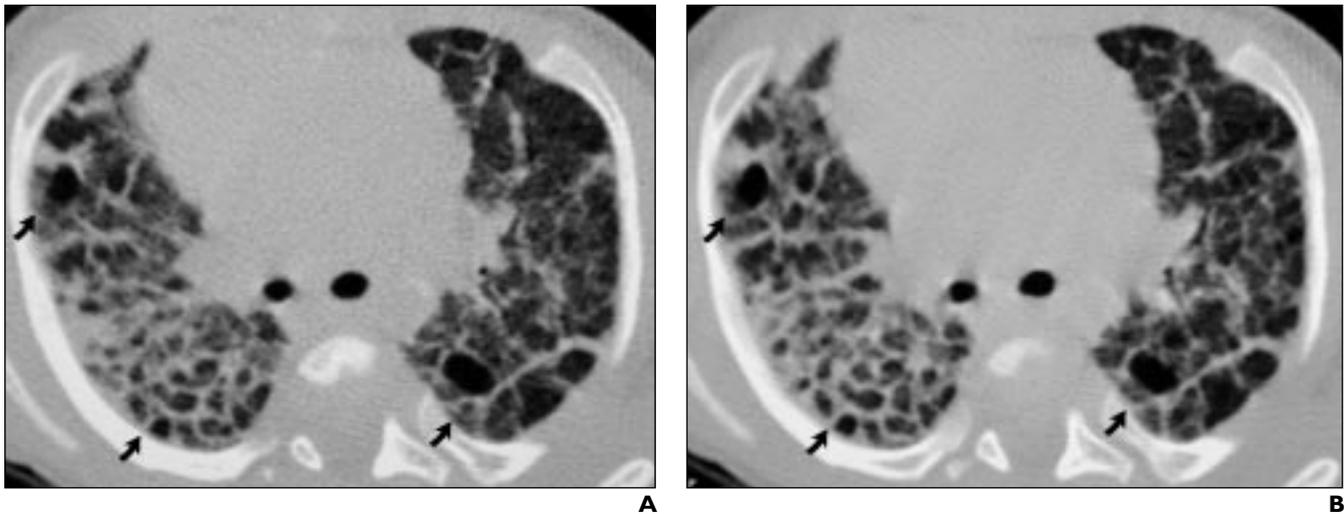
3-month-old female infant with bronchopulmonary dysplasia. A and B, High-resolution CT scans of chest obtained with 50 mAs (A) (average image quality score, 2.36) and with 180 mAs (B) (average image quality score, 2.57) reveal no significant difference in image quality between A and B. Interstitial thickening and areas of hyperlucent lung (arrows) producing pseudocystic appearance are clearly visible on both images.
